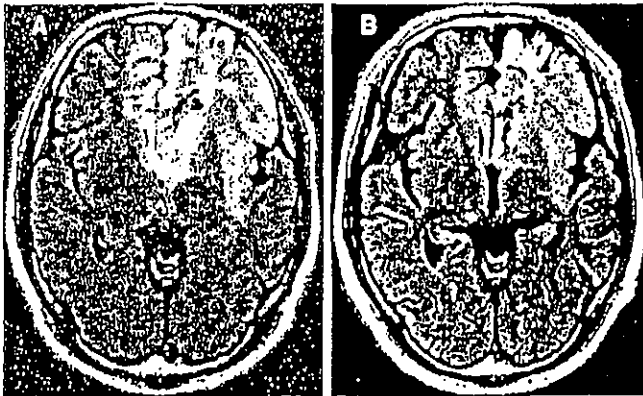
MRI scans in a representative methylated MGMT promoter case. This 43-year-old man, who had a generalized tonic seizure, underwent stereotactic biopsy of a left frontal AA on February 4, 1999 (A). After radiation (60 Gy) and five courses of chemotherapy (ACNU/interferon- β), the tumor, which was hyperintense on T2-weighted MRI scans but not on Gd-DTPA-enhanced MRI scans, was decreased in size (B).
